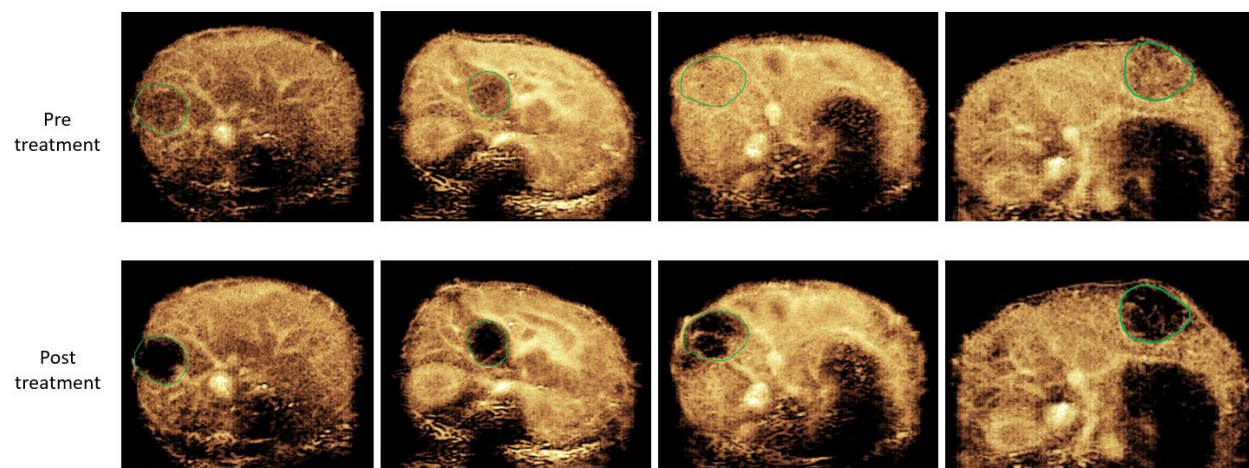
Representative images displaying perfusion loss in response to cavitation treatments. Maximum-intensity projection contrast-enhanced ultrasound images before and after cavitation treatment are shown, with the tumor highlighted by a green region of interest.
